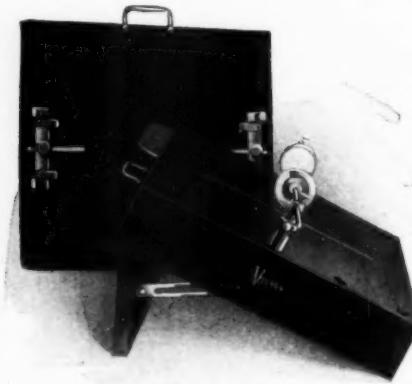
Victor-Allen roentgenographic head-rest
